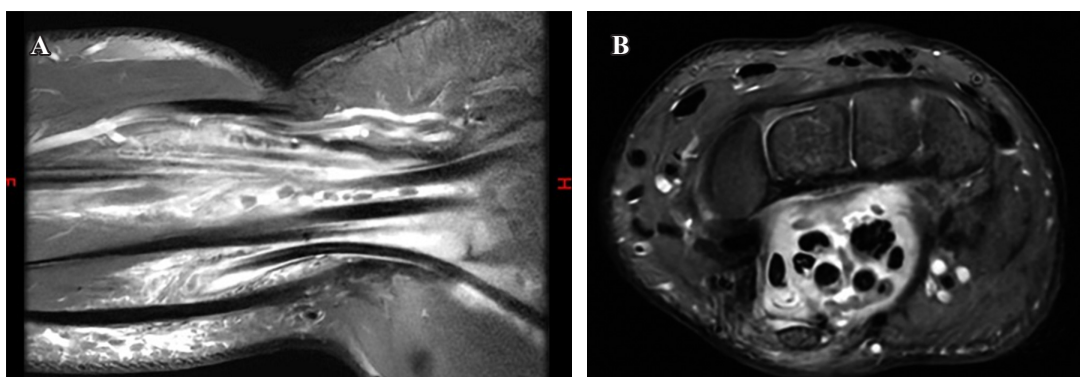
A) Magnetic resonance imaging of the hand, coronal section. Granulomatous synovitis is observed, with «rice grain» figures at the bases of the metacarpals extending to the distal portion of the intermediate column of the radius. B) Magnetic resonance imaging of the hand, transverse section. Granulomatous synovitis is observed, with «rice grain» figures at the bases of the metacarpals extending to the distal portion of the intermediate column of the radius.
